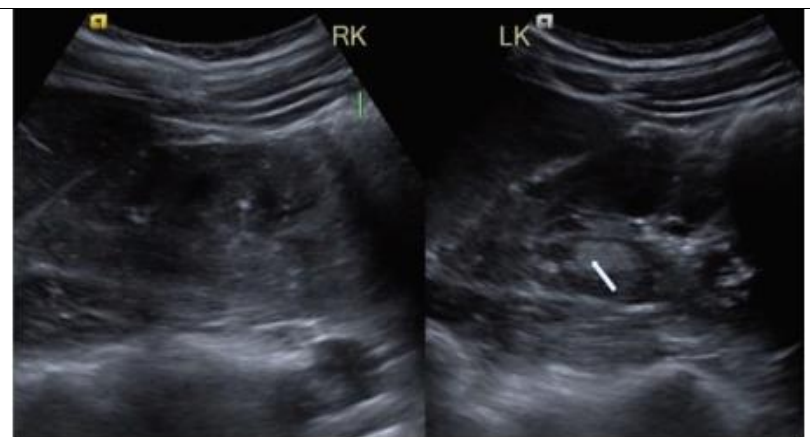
Left kidney ultrasonography (USG) showing many minor (2–3 mm) echogenic foci on both sides, as well as a single hyperechoic angiomyolipoma (white arrow) in the interpolar cortex and possible smaller angiomyolipomas.
